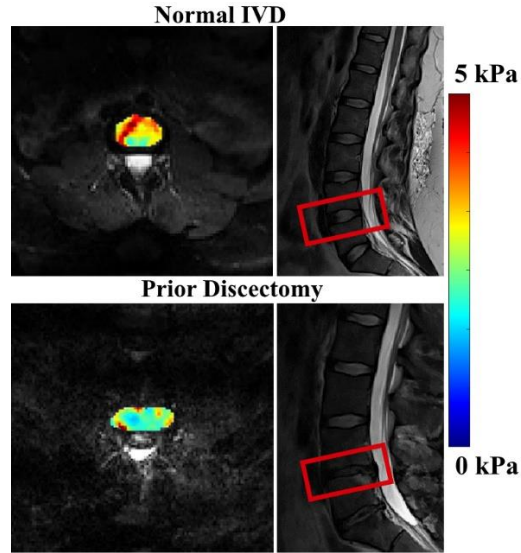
$|G^*|$ at 100Hz in a healthy IVD (top) and an IVD with degeneration from a prior discectomy (bottom), location shown in red on the associated Sagittal T2-weighted structural scan.
